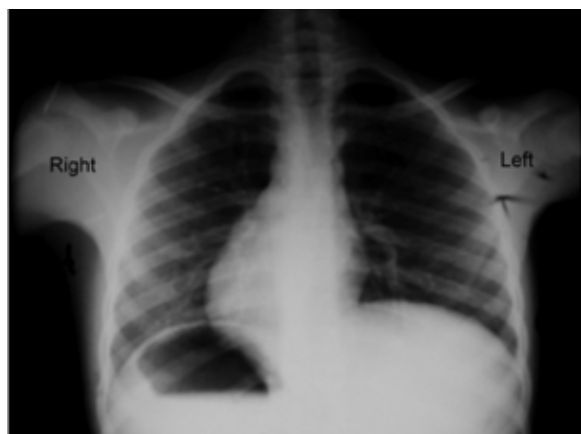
The edited postero-anterior chest X-ray properly oriented
